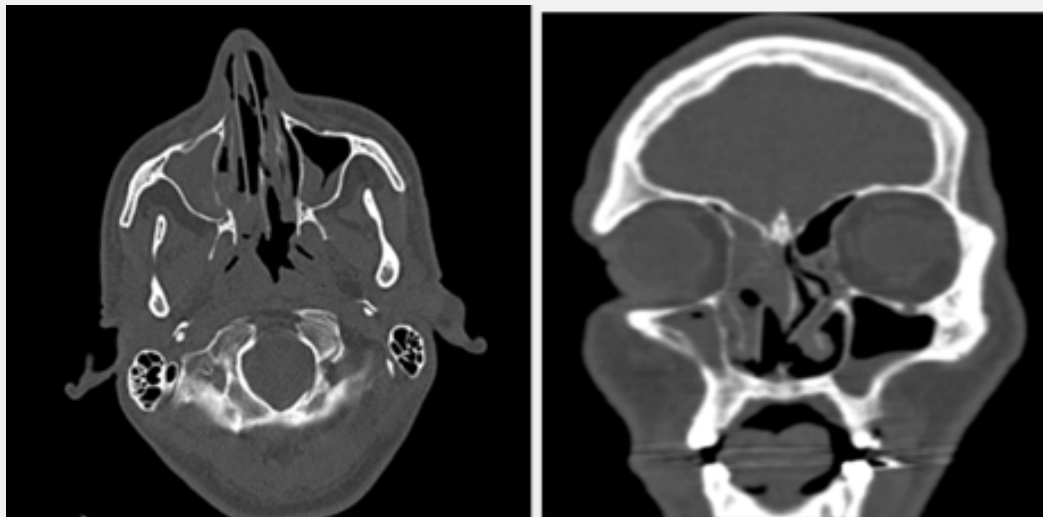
Para- nasal CT scan showing pan sinusitis with bone destruction.
